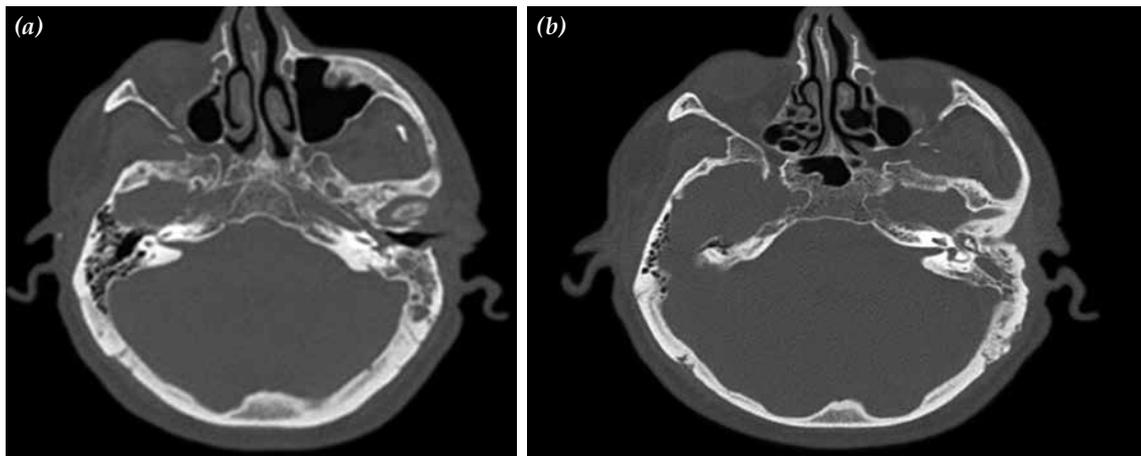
(a, b) Temporal high-resolution computed tomography showing a mass lesion originating from middle ear extending to external ear canal with no prominent erosion or sclerosis of mastoid cortex.
